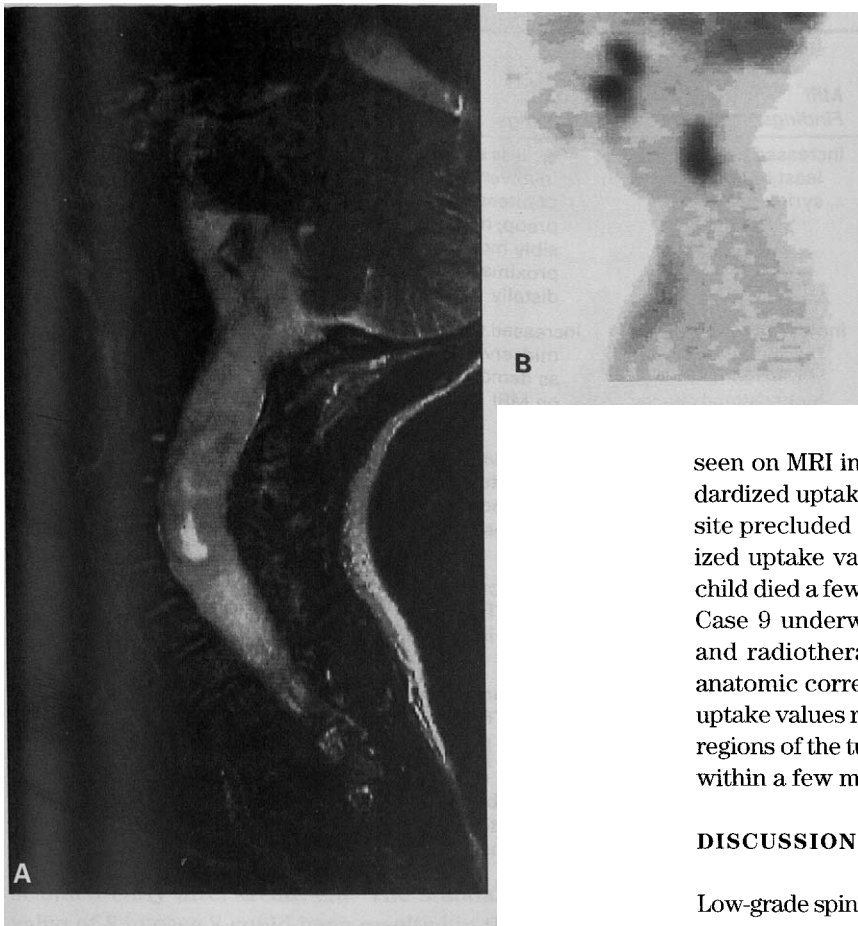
Case 13. *A*, Fast spin echo T₂-weighted MRI sagittal cut (TR 2200; TE 150). Low-grade glioma from the medulla to T6 with hyperintensity and swelling above and below the lesion. *B*, PET imaging (sagittal cut) confirming an area of increased FDG uptake correlating with MRI findings.
